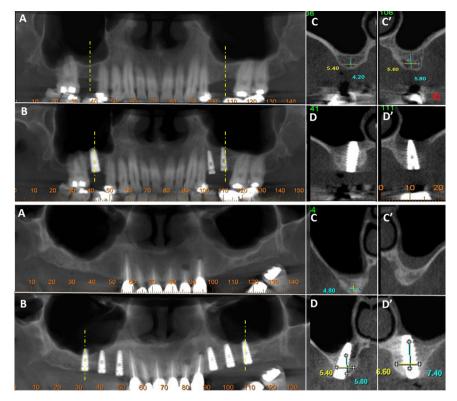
Radiographic evaluation of new bone consolidation on the maxillary sinus floor. Preoperative and postoperative panoramic CT scan views of two cases are presented. (A) Preoperative bilateral partially edentulous maxillary posterior sites. (B) Postoperative CT scan panoramic view at 6 months after maxillary sinus lifting and implant insertion. (C, C') Preoperative coronal or sagittal sections of the respective CT scan of the right and left maxillary sinus. (D, D') Postoperative coronal or sagittal sections of the respective CT scan of the right and left maxillary sinus after 6 months.
